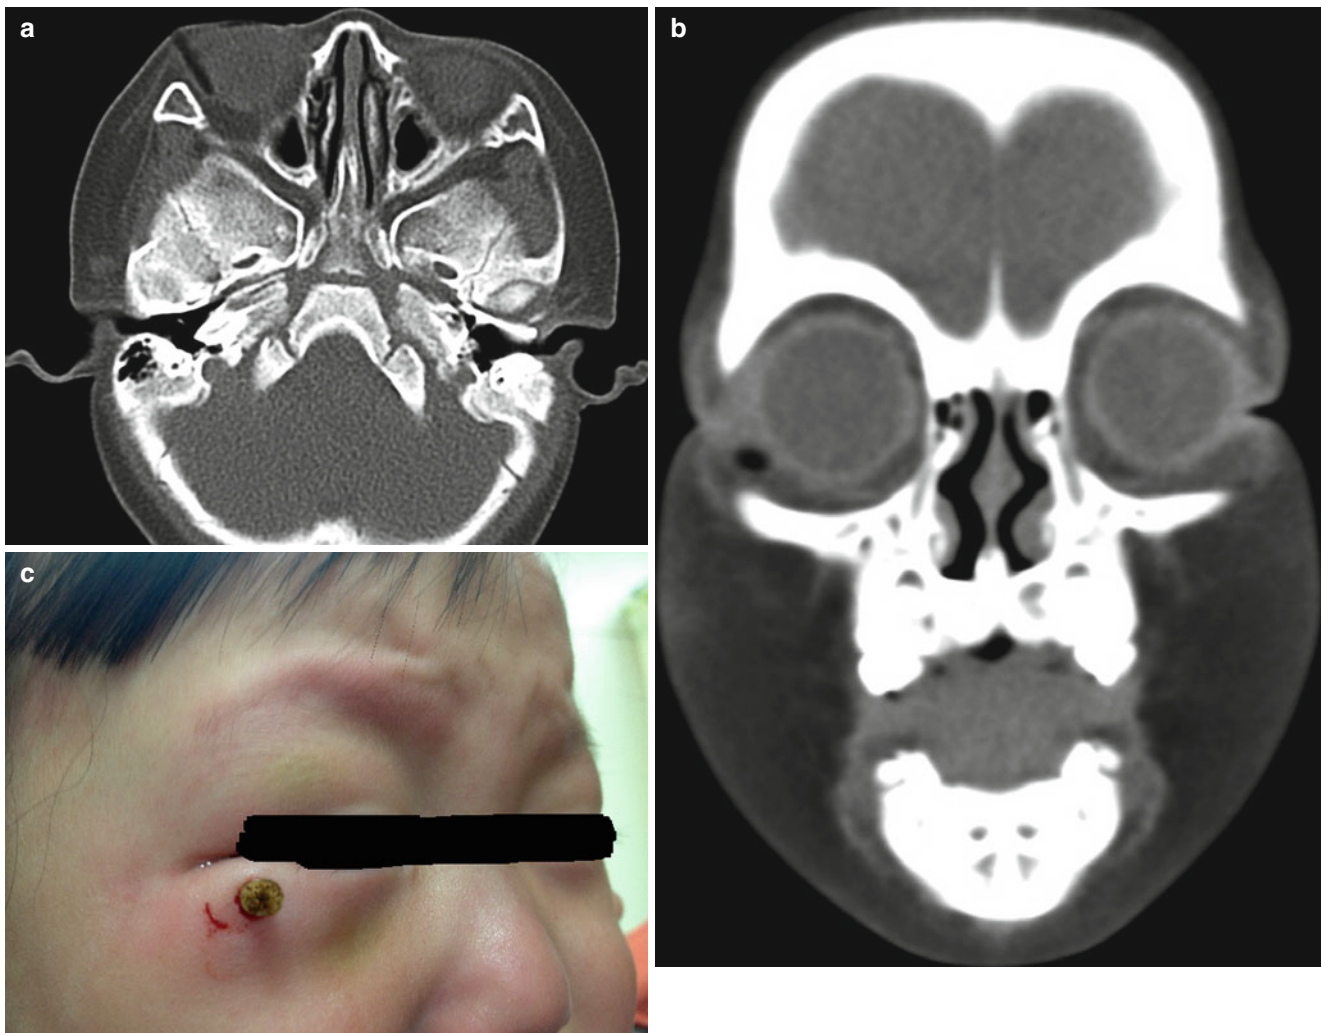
Orbital foreign body (chopstick) in a 1-year-old girl. (a, b) Axial (a) and coronal (b) CT images show a tubular low-attenuating foreign body in the right orbit just inferolateral to the right eyeball. (c)
